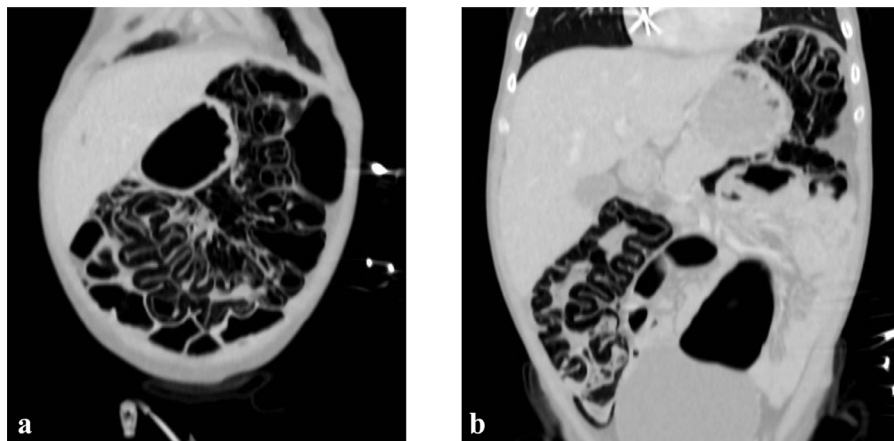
Coronal reconstruction of abdomen contrast-enhanced CT images in lung window shows the presence of pneumatosis cystoides intestinalis of the cecum, ascending and transverse colon, hepatic and splenic flexure.
